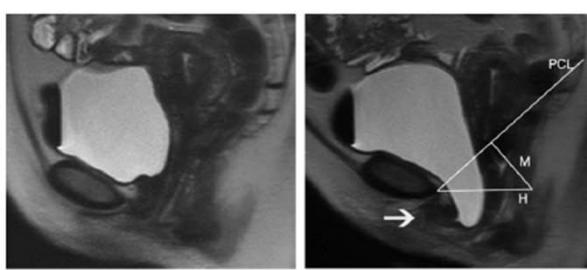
Grade 1 pelvic floor relaxation and descent, grade 2 cystocele, urethrocele, and urethral hypermobility in a 46-year-old multiparous woman with urinary frequency and urgency, constipation, and pelvic pain. Midsagittal single-shot fast SE MR images obtained with the patient at rest (a) and straining (b) demonstrate an anteroposterior hiatal dimension (H line) of 6.1 cm and a pelvic floor descent (M line) of 2.0 cm, findings that are consistent with grade 1 pelvic floor relaxation and descent. The bladder is 3.1 cm below the H line (consistent with a grade 2 cystocele), and the urethra is below the H line (consistent with a urethrocele). Urethral hypermobility is noted due to the horizontal configuration of the urethra during straining (arrow in b).
